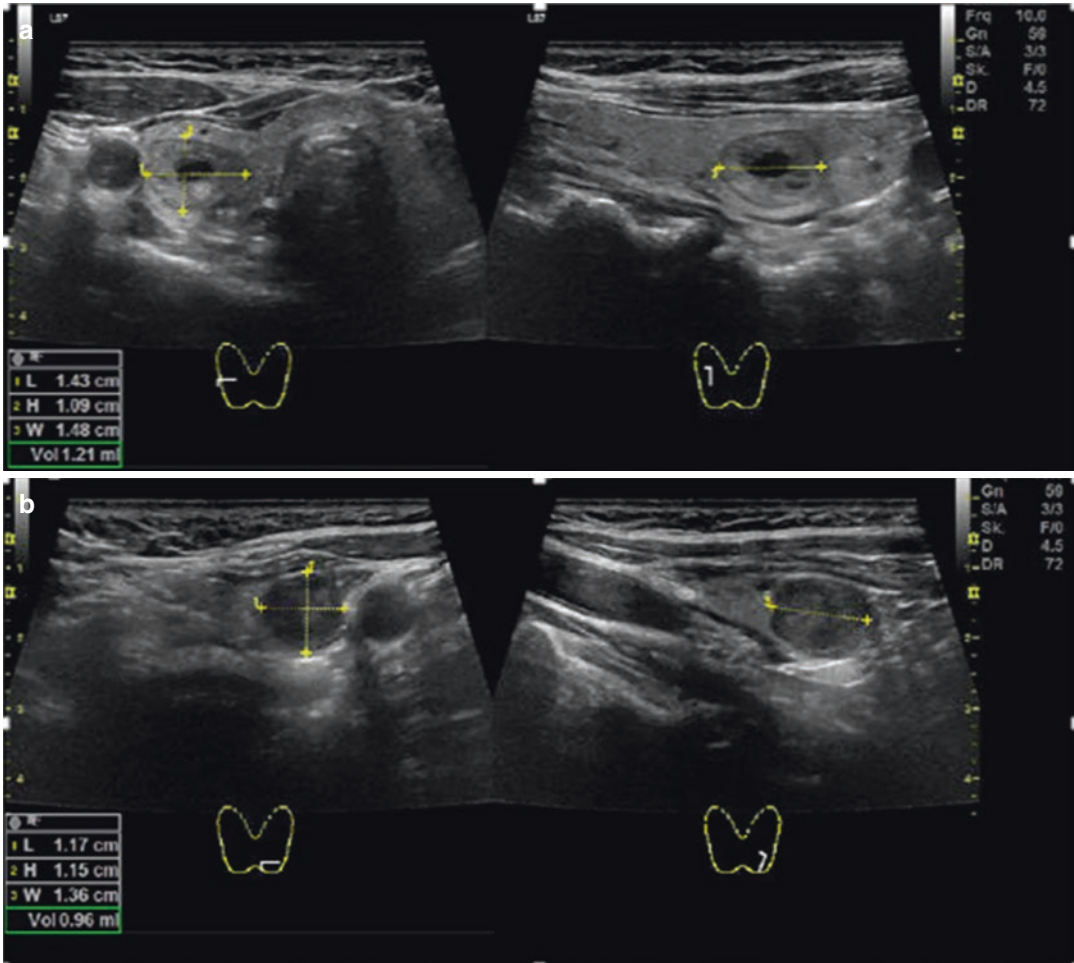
(a–c) A 59-year-old female patient with multinodular goiter, TSH 0.50 mU/l, Calcitonin <1.0 pg/ml. (a) B-mode sonography showed two thyroid nodules (upper images: right central lobe, 14 x 10 x 15 mm, EU-TIRADS 3; lower images: left lower pole, 12x12x14 mm, EU-TIRADS 4). (c) ^{99m}Tc -pertechnetate scintigraphy with 64 MBq, both thyroid nodules were identified as hypofunctioning (black circles). (d) MIBI imaging: planar
